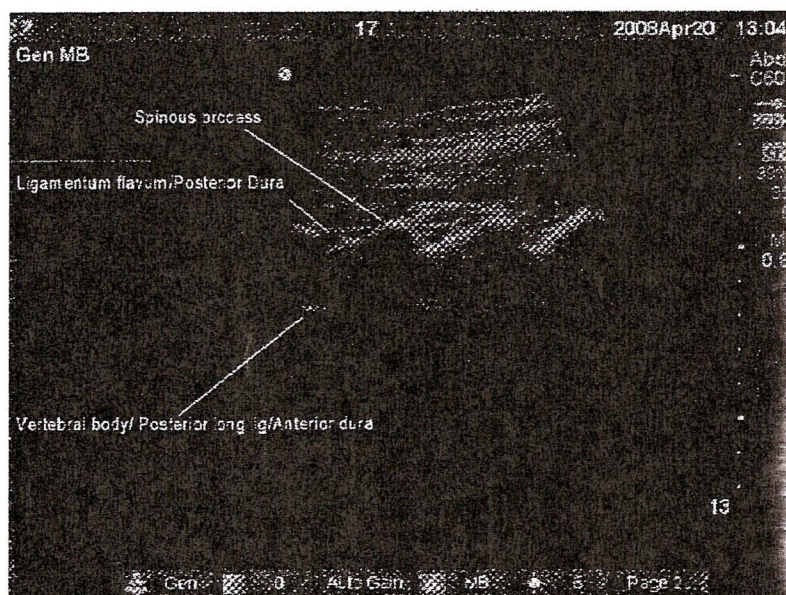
Longitudinal median ultrasound plane.
